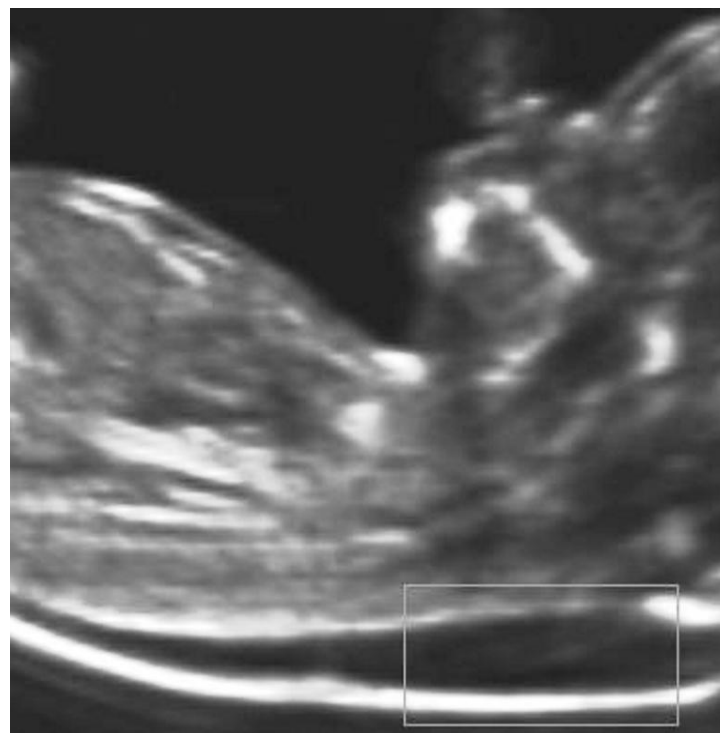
Two dimensional ultrasound images with ultrasound marker, nuchal translucency.
